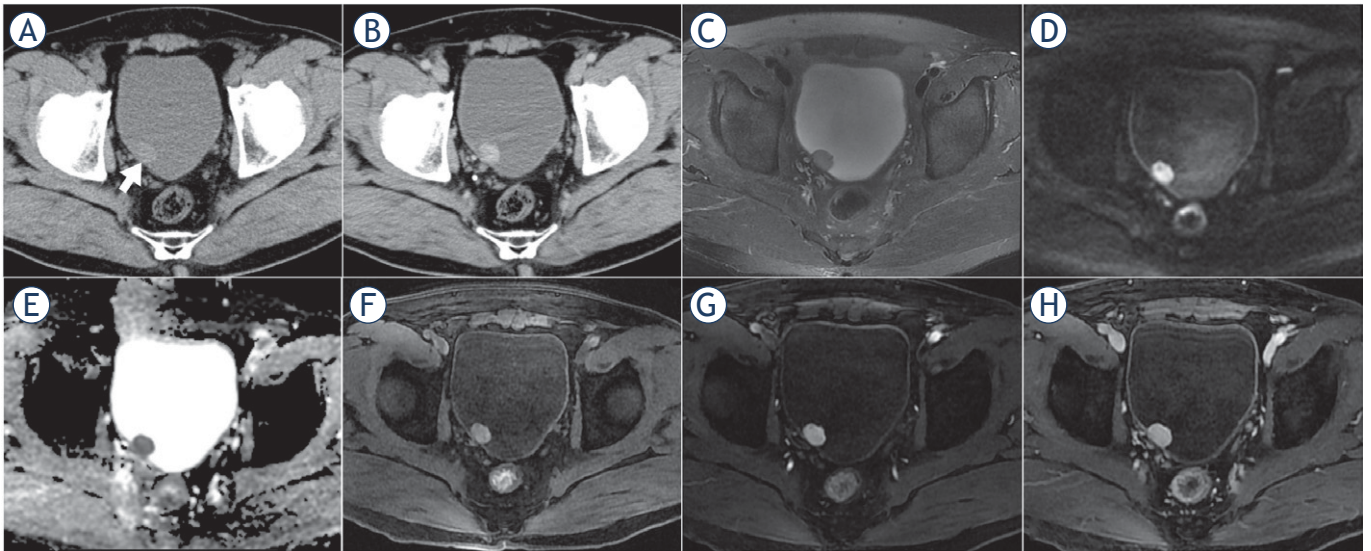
CT and MR images of a 61-year-old male patient with bladder paraganglioma. The tumour was located in the posterior bladder wall, oval, well-defined margin, protruding into the bladder cavity with broad-base attachment to the bladder wall (short arrow). The lesion showed slight hypodensity and obvious enhancement on axial pre- and post-contrast-enhanced CT images (A, B), homogenous slight hyperintensity on T2-weighted images (T2WI) (C), marked hyperintensity on diffusion-weighted images (DWI) (D), hypointensity on apparent diffusion coefficient (ADC) maps (mean ADC value, $0.870 \times 10^{-3} \text{ mm}^2/\text{s}$) (E), hyperintensity compared to the *gluteus maximus* on T1-weighted images (T1WI) (F) and "fast in and slow out" on dynamic contrast-enhanced MRI (G, H).
